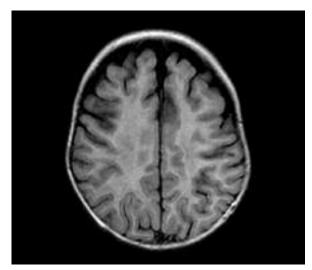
FLAIR weighted MR images – white matter intensity of signal does not show pathological changes, thin cerebral cortex in frontal areas.
